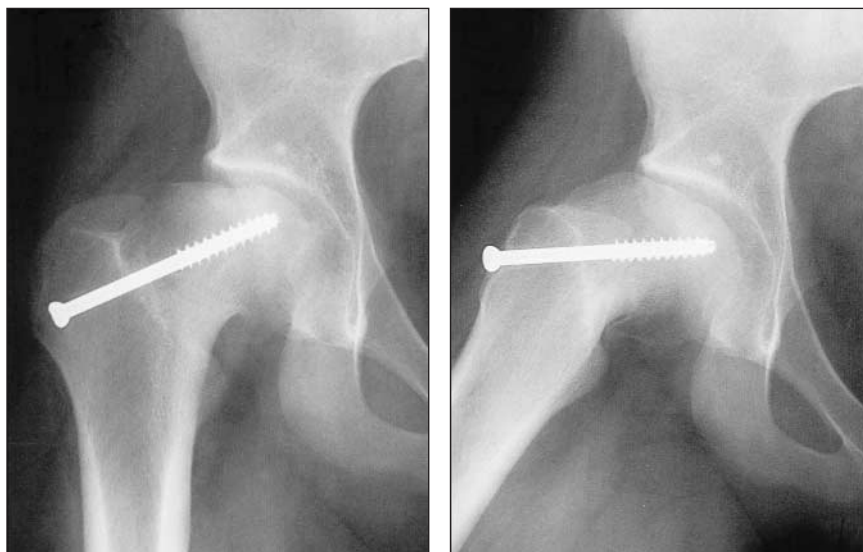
Radiographs of a 14-year-old boy with a stable slip. The 2 cannulated screws were changed to 1 screw the day after the first operation because of joint penetration. The radiolucent area involves the anterolateral area of the head on both the anteroposterior (left x-ray) and frog-leg lateral (right x-ray) views.
